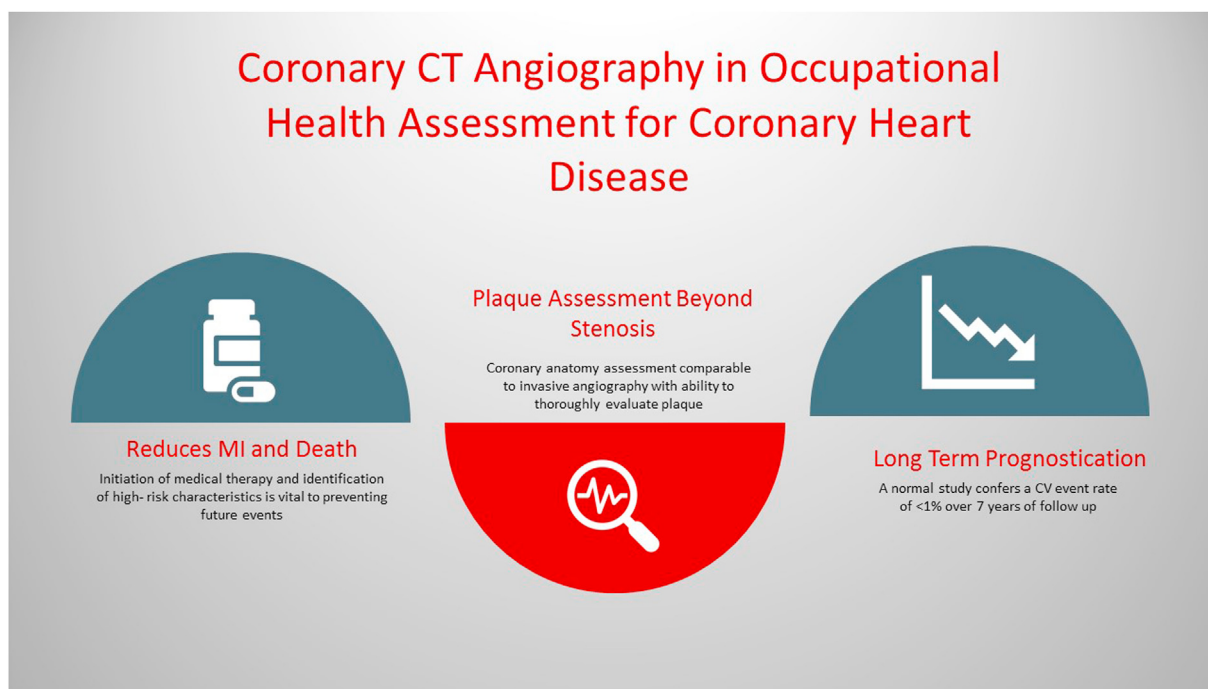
Role of coronary CT in occupational health assessment.
